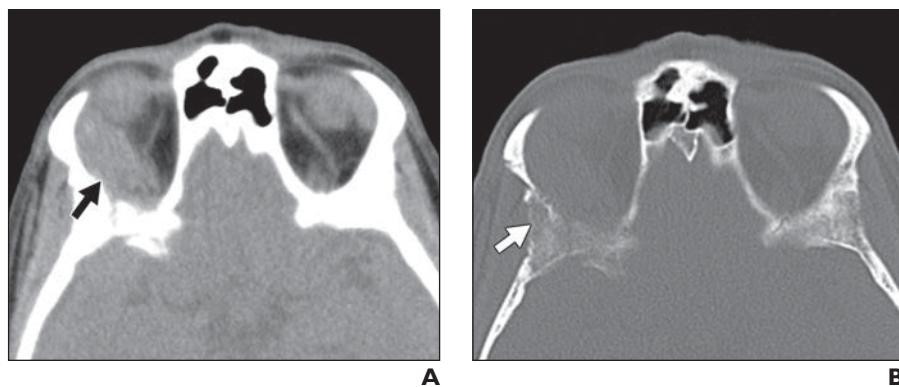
Adenoid cystic carcinoma. A–D, Axial (A and B) and coronal (C and D) unenhanced CT images show right orbital lobe lacrimal gland mass (black arrows, A and D) with permeative destruction of right sphenoid bone (white arrows, B and C).
